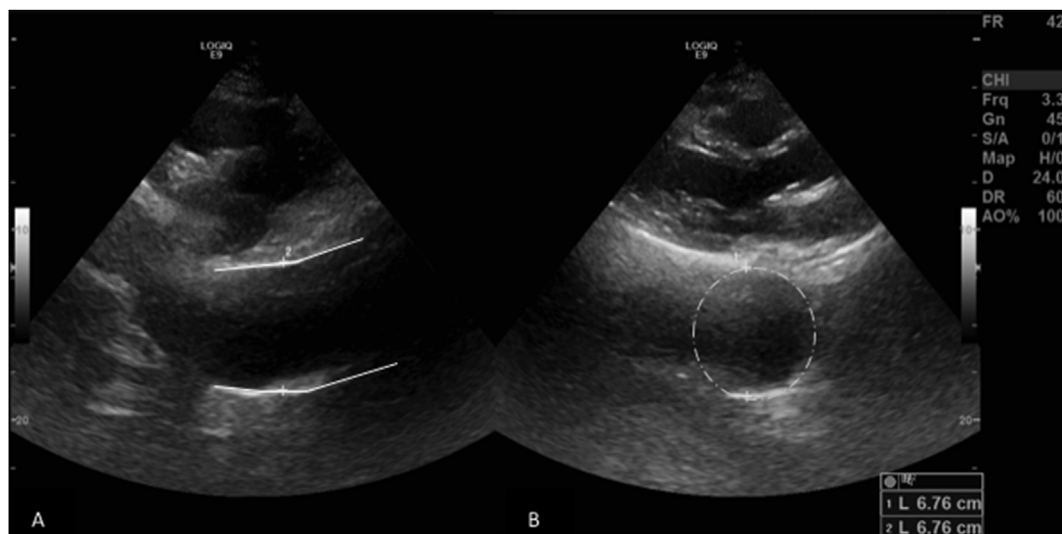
Longitudinal (A) and transverse (B) view of a 6.76 cm aneurysm in the mid portion of the descending aorta. This aneurysm was detected using a standard parasternal long axis view (B) and a modified parasternal long axis view (A).
